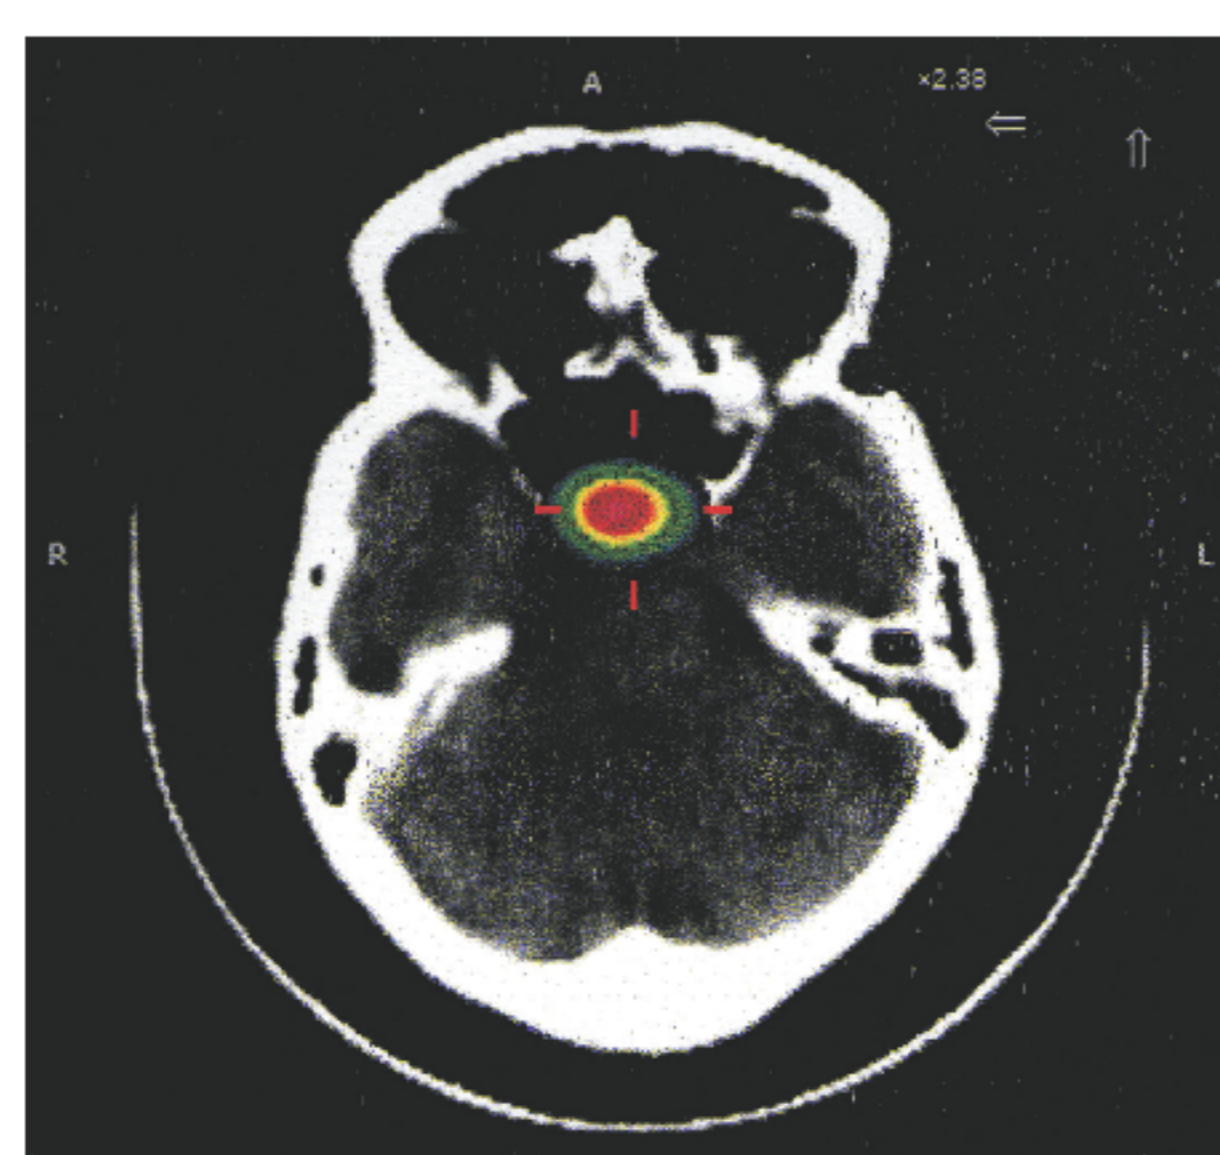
Somatostatin receptor scintigraphy (SSTR 2) in patient with NFPA
